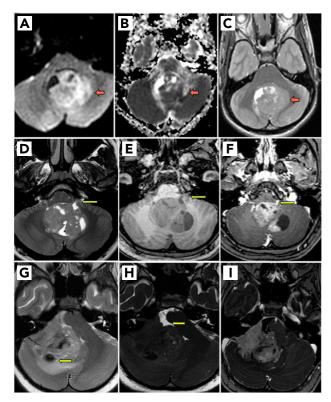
MRI examples of WNT-activated medulloblastoma. (A-C) 10-year-old female with a fourth ventricular tumor: (A) axial diffusion-weighted, (B) ADC map, and (C) T2-weighted images demonstrate invasion of the left dentate nucleus (arrow). (D-F) 10-year-old male with a fourth ventricular tumor: (D) axial T2-weighted, (E) precontrast T1-weighted, and (F) postcontrast T1-weighted images demonstrate extension into the left foramen of Luschka. (G-I) 9-year-old female with a right cerebellopontine angle tumor: (G) axial T2-weighted, (H) CISS, and (I) postcontrast T1-weighted images demonstrate a mass in the right CP angle. On T2 (G), the internal hypointense signal represents intratumoral hemorrhage (arrow). On CISS (H), note the CSF cleft between the tumor and the pons (arrow).
